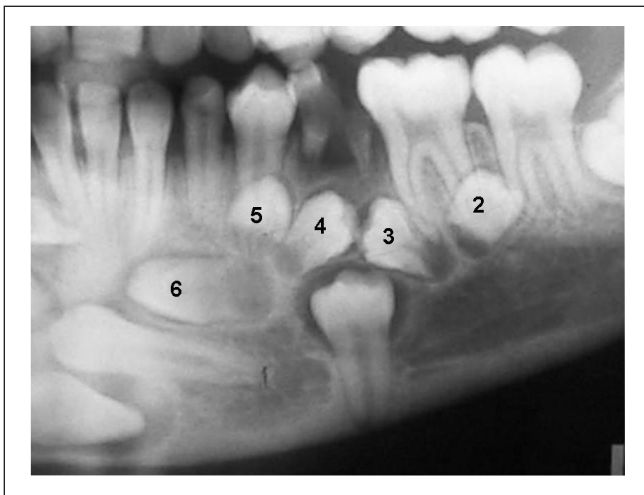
b) Left mandible. Five supernumeraries are observed in this magnified area of the original radiograph.
